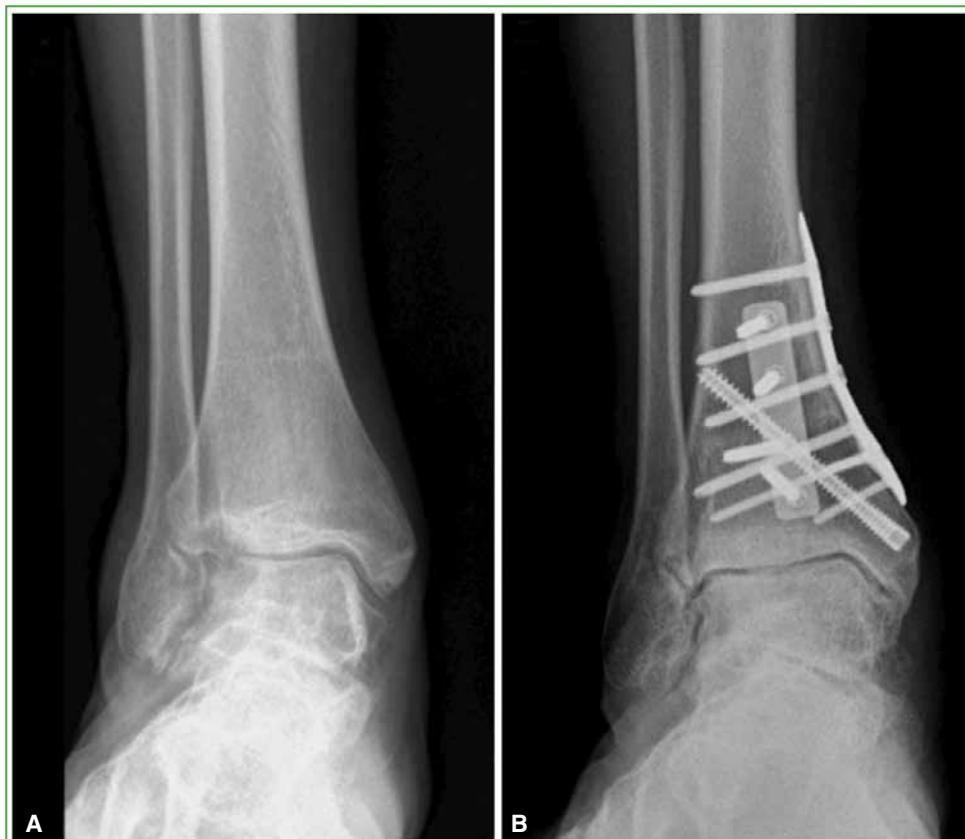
Takakura Stage IIIA. A. Preoperative ankle radiograph, AP view. B. Anteroposterior ankle radiograph, 6 years after internal supramalleolar closing-wedge varus osteotomy.
